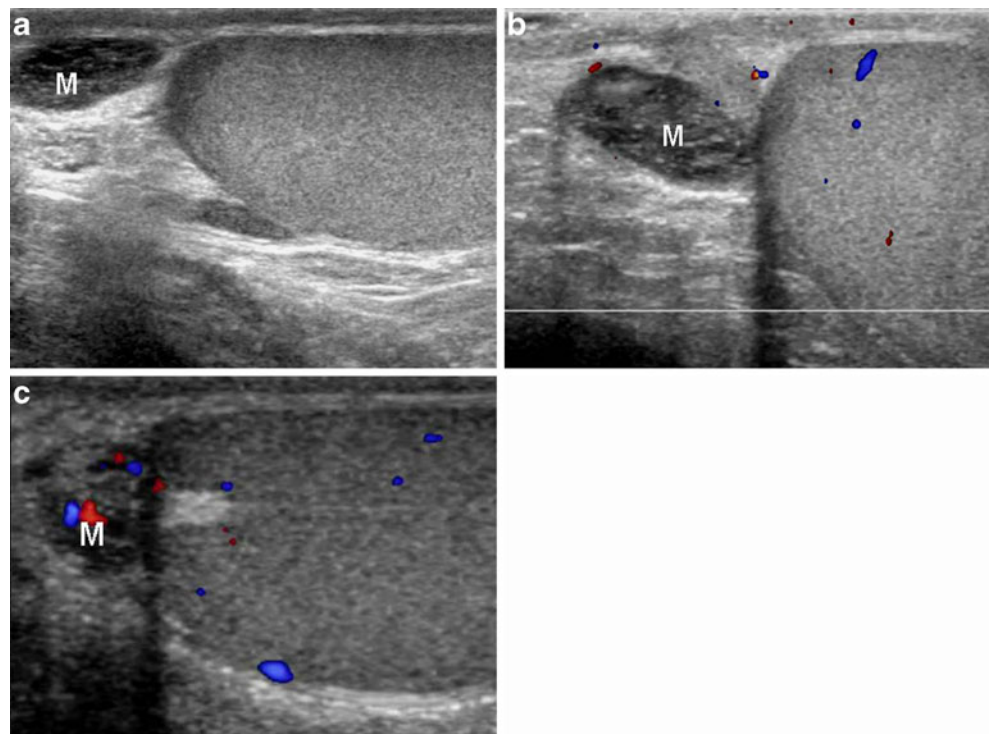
A 13-year-old man with left testicular appendage with torsion suffered from sudden-onset left scrotal pain. a Longitudinal US of the left testis shows hypoechoic mass-like lesion (M) at the left testis upper polar area. b Colour Doppler US shows absent vascularity. Radiologic primary diagnosis was testicular appendage with torsion. Conservative treatment was performed. c Follow-up US after 1 week shows decreased size of the presumed torsed testicular appendage (M). His pain had also been subsided
